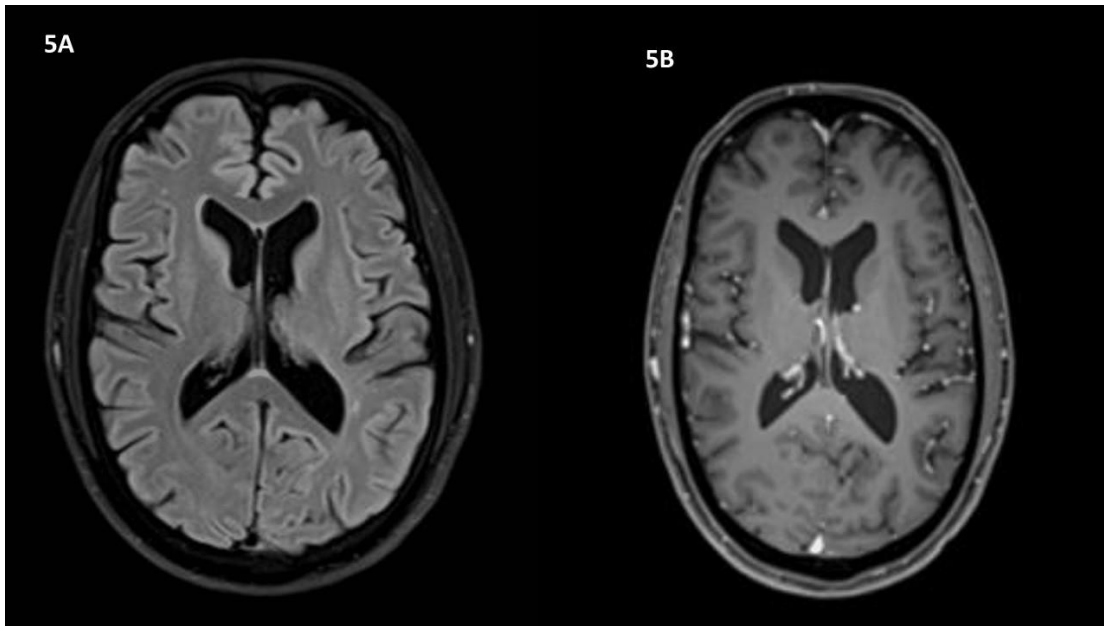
Magnetic resonance imaging T2 FLAIR axial image. 6 weeks post-steroid treatment showing resolution of white matter edema.
